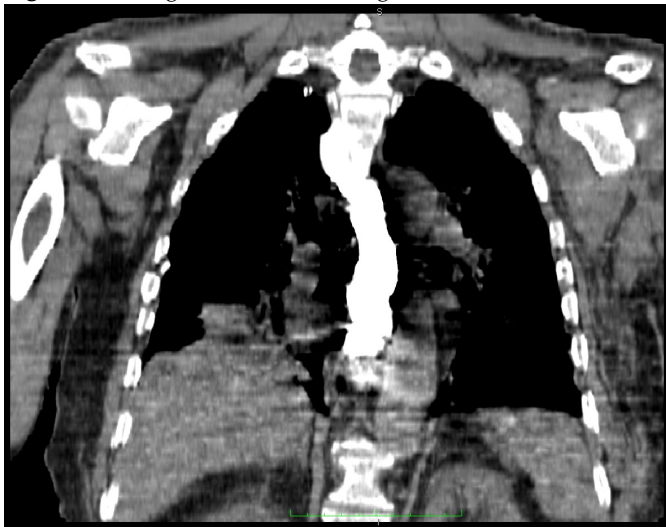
CT showing the absence of passage of contrast into the mediastinum.
